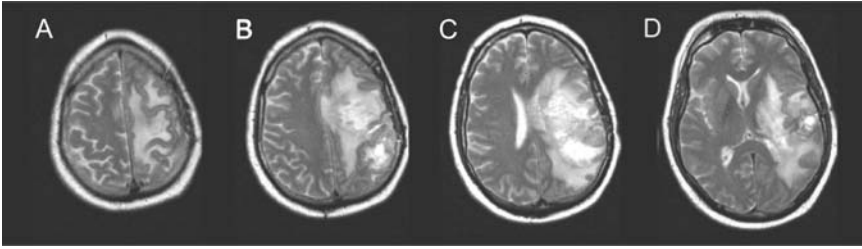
A structural MRI scan (axial MRI T2-weighted) of the brain (top to bottom presented from left to right) showing a malignant high-grade tumour with associated oedema which has invaded most of the left cerebral hemisphere (shown as a large bright region on the right side of the image) in scans taken from different levels through the brain.
